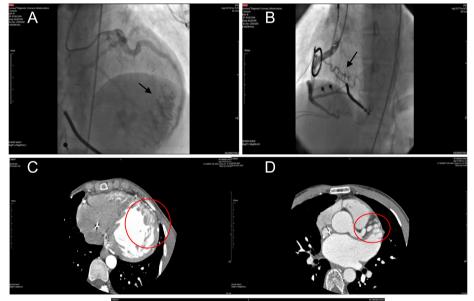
Area pointed by the arrow on Figure (A): During right/left catheterization, coronary angiographic images show fistulization extending into the left ventricle originating from the distal left anterior descending branch (LAD). Area pointed by the arrow on Figure (B): Fistula originating from the right coronary artery (RCA). In the circled area on Figure (C-D-E): Coronary computed tomography angiography images show the course of the left descending artery (LAD) fistula within the left ventricular wall and its connection with the left ventricular cavity.
